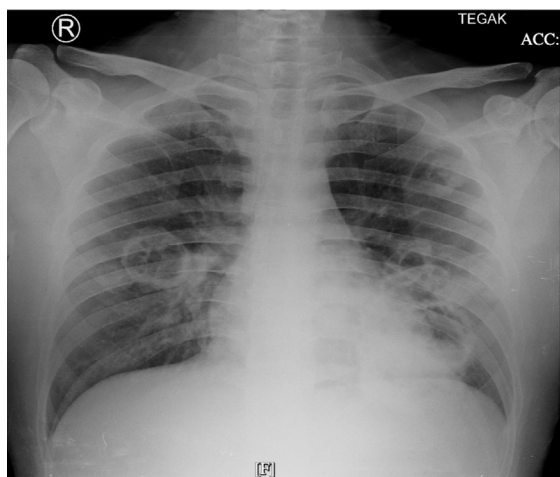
Initial chest radiography revealed multiple cavitary lesions in both lung fields.
